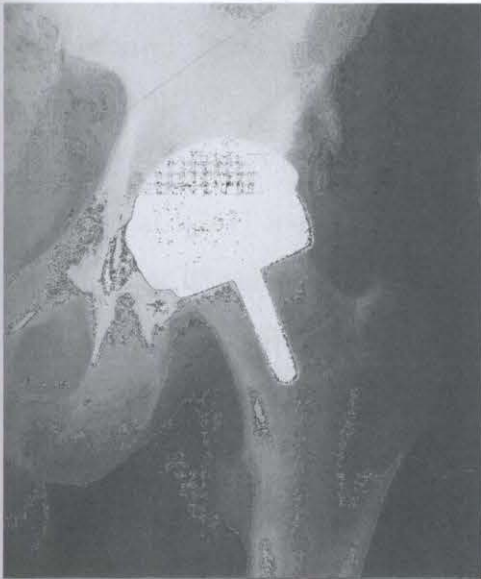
Anteroposterior radiograph showing the ideal position of the femoral component of the hip resurfacing arthroplasty [233]
